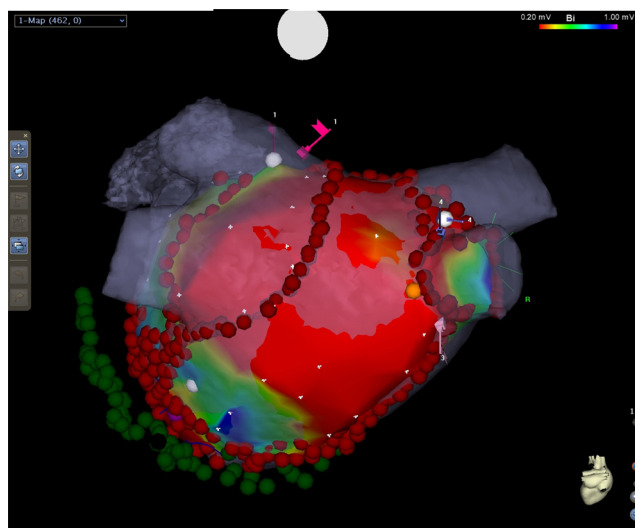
CARTO electroanatomical mapping system. CARTO-Merge – image integration (electroanatomical voltage map and CT 3D-reconstruction of left atrium). Catheter ablation for persistent atrial fibrillation. Red dots – ablation points. Green dots – ablation points in coronary sinus. Orange dot – oesophagus in close proximity with posterior wall of left atrium.
